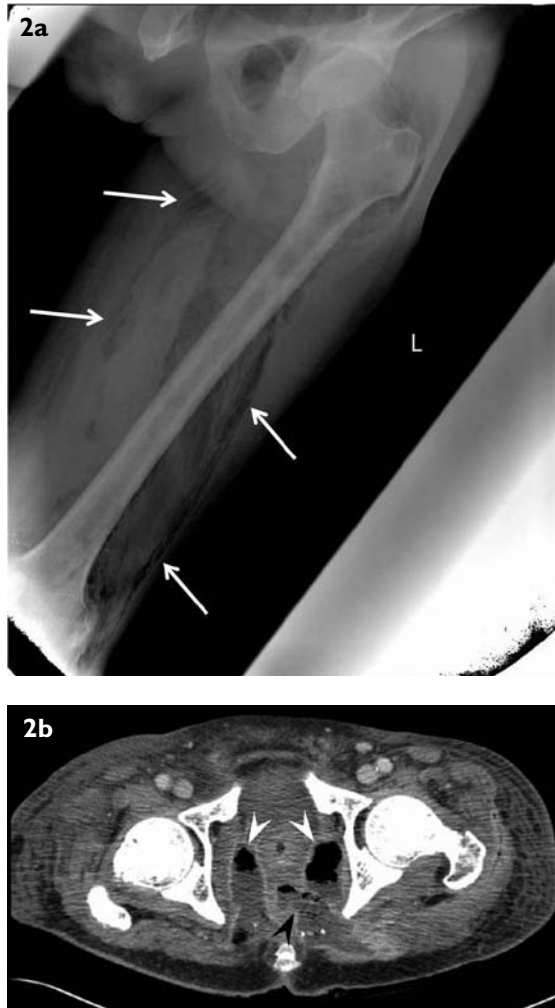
(a) Left leg radiograph shows both subcutaneous and intermuscular gas (white arrows) (b) Axial CT image of the pelvis shows a large perforation (black arrowhead) of the left posterolateral wall of the lower rectum with gas and faeces tracking into the ischioanal fossae and left gluteal region (white arrowheads).
